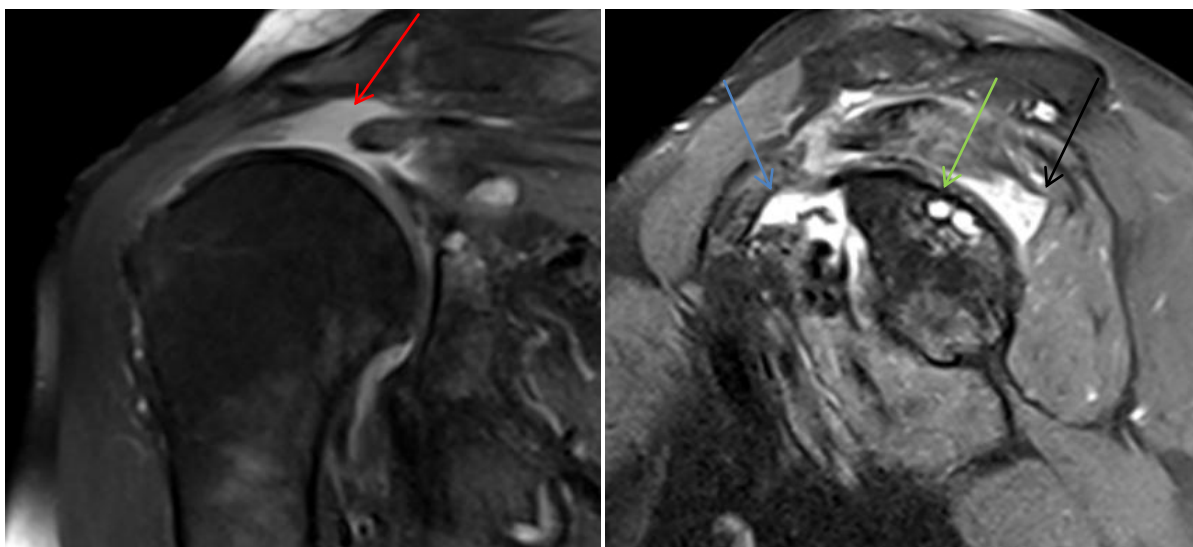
Above PD FAT SAT MR images show complete tear of supraspinatus at myo-tendinous junction (red arrow) and partial tear of subscapularis (blue arrow) and infraspinatus (black arrow). Subchondral cystic changes are noted involving glenoid (green arrow).
